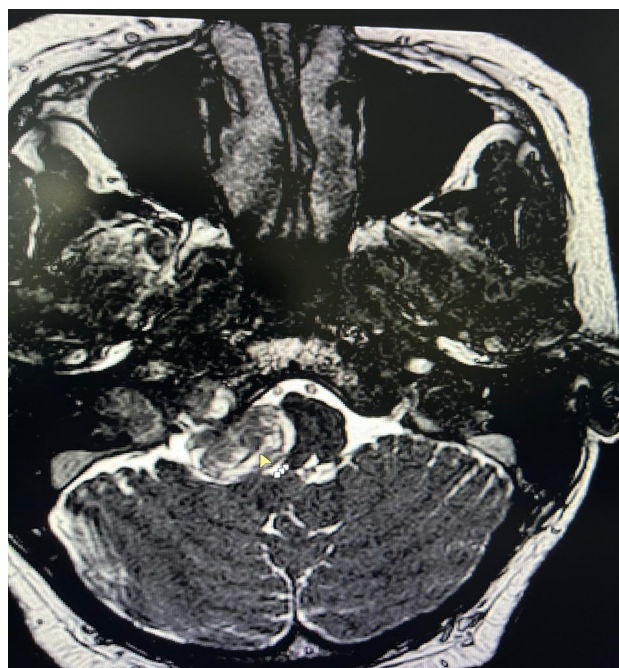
Contrast-enhanced axial MRI demonstrating a heterogeneously enhancing right cerebellopontine angle mass extending into the internal auditory canal, with mass effect on the adjacent brainstem, consistent with vestibular schwannoma.
